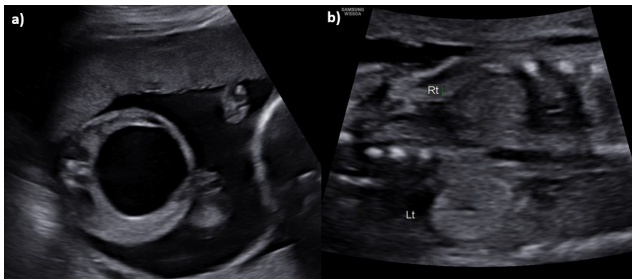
a) Axial sonogram of the pelvis showing an abdominopelvic cystic anechoic formation (41x37x37 mm), indicative of megacystis. b) Coronal sonogram of kidneys that appear with a hyperechogenic echostructure.
